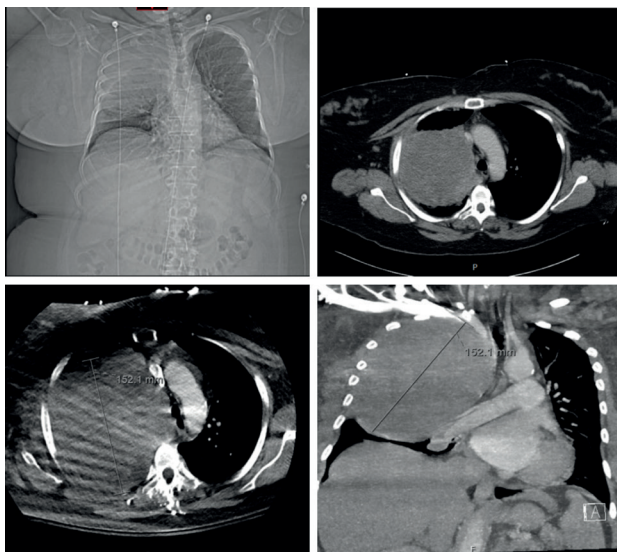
Chest X-ray showing right lung mass [top left]; CT with contrast: mass 11.2 × 10.5 × 11.2 cm [top right]; Repeat chest CT w/co showing 15-cm right lung mass axial view [bottom left]; and coronal view [bottom right].
